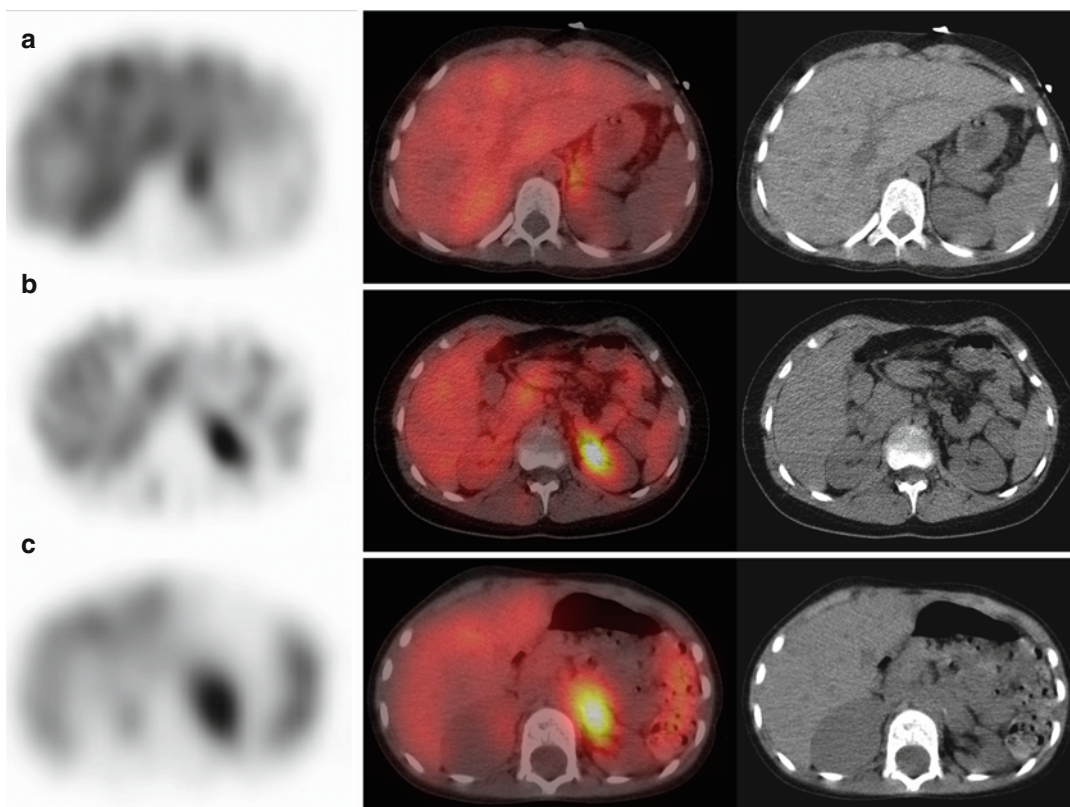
Iodine-123-MIBG SPECT/CT images in three different patients with focal uptake in the left retroperitoneum. (a) Physiologic uptake in the normal left adrenal gland. (b) Physiologic accumulation in the left renal pelvis reflects urinary excretion of tracer.
